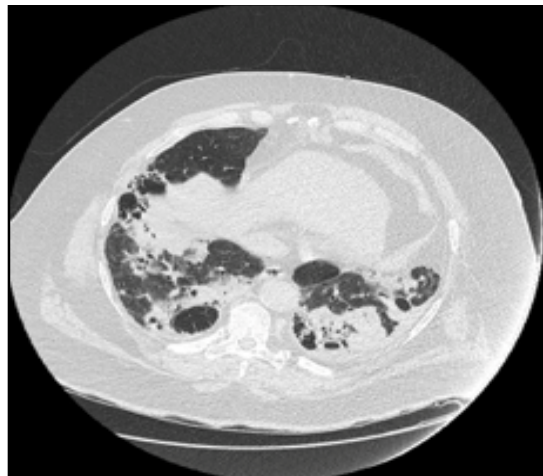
Last Chest CT showing again areas of peripheral consolidation, with central lucency and pleural thickening
